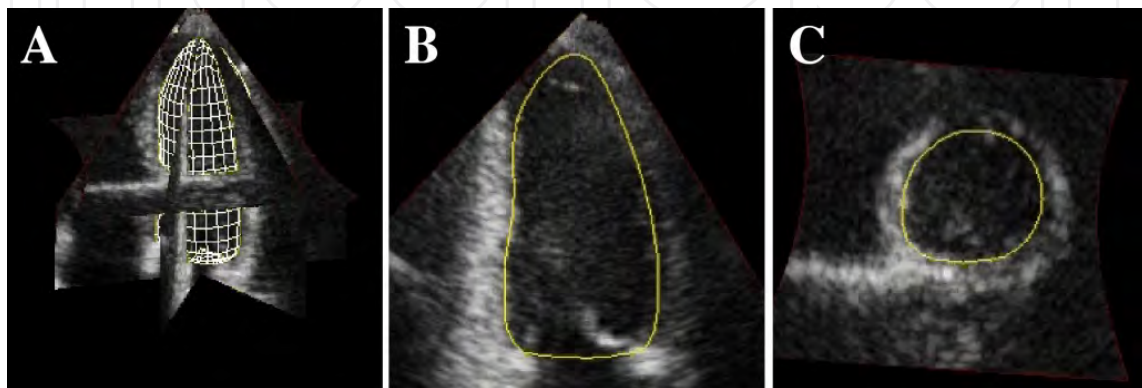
A 3D model of the left ventricle (A) matched in real-time to 4D Ultrasound shown here as slices in 3D (A) and 2D (B and C). Source: Orderud [95].
